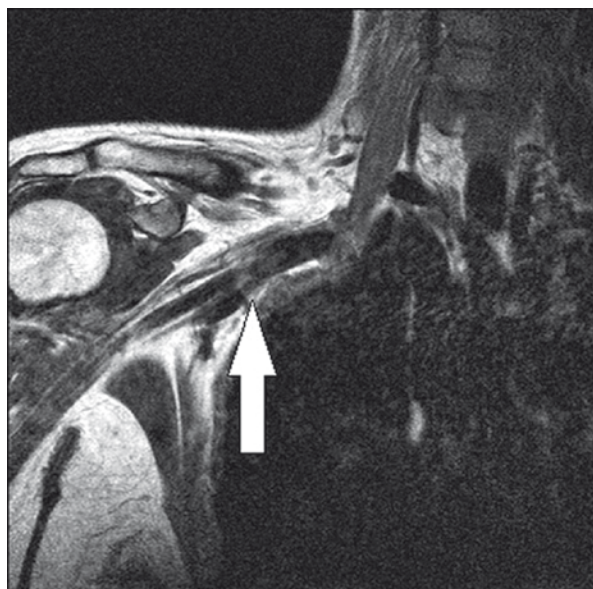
Coronal T1-weighted magnetic resonance images of the right brachial plexus showed signs of compression (white arrow) by the bulging portion of the mid-clavicle
